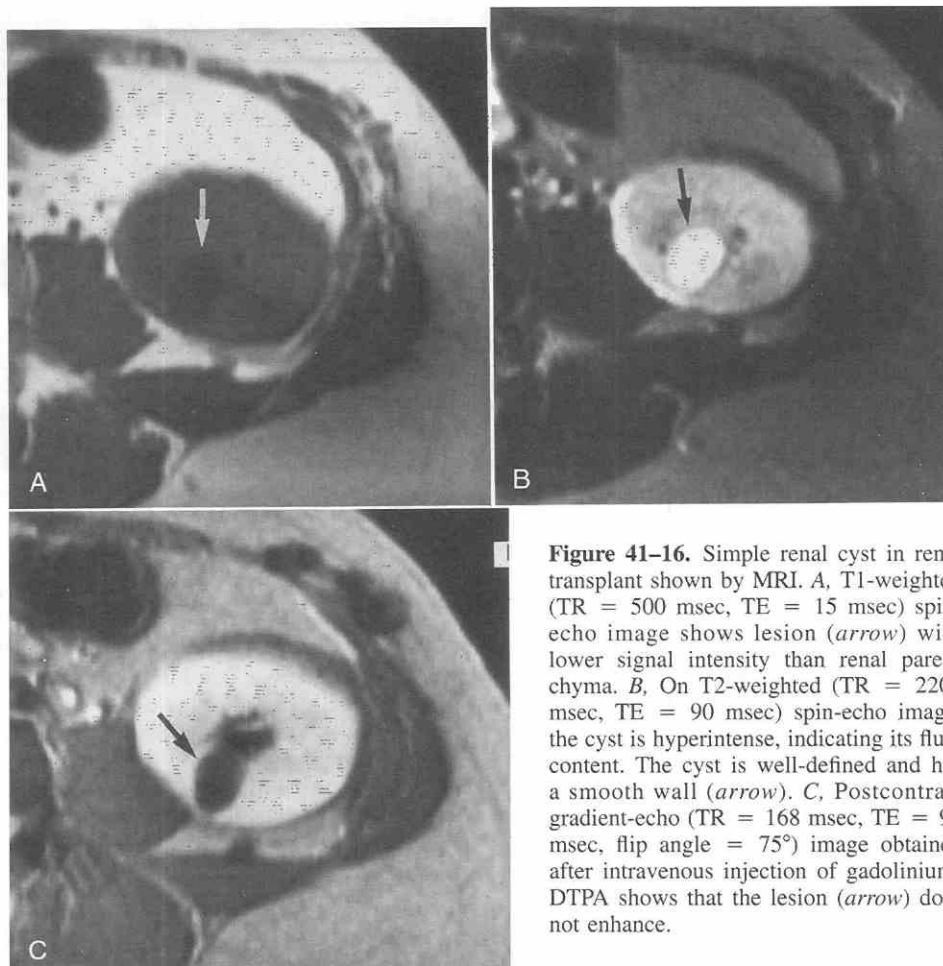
Simple renal cyst in renal transplant shown by MRI. *A*, T1-weighted (TR = 500 msec, TE = 15 msec) spin-echo image shows lesion (arrow) with lower signal intensity than renal parenchyma. *B*, On T2-weighted (TR = 2200 msec, TE = 90 msec) spin-echo image, the cyst is hyperintense, indicating its fluid content. The cyst is well-defined and has a smooth wall (arrow). *C*, Postcontrast gradient-echo (TR = 168 msec, TE = 90 msec, flip angle = 75°) image obtained after intravenous injection of gadolinium-DTPA shows that the lesion (arrow) does not enhance.
